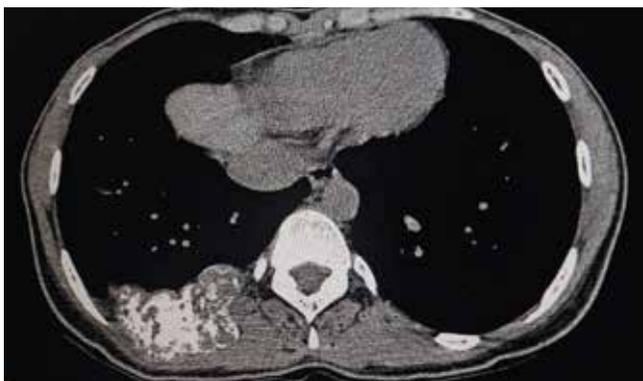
b) Axial CT-cut showing expansile 9th right rib lesion
